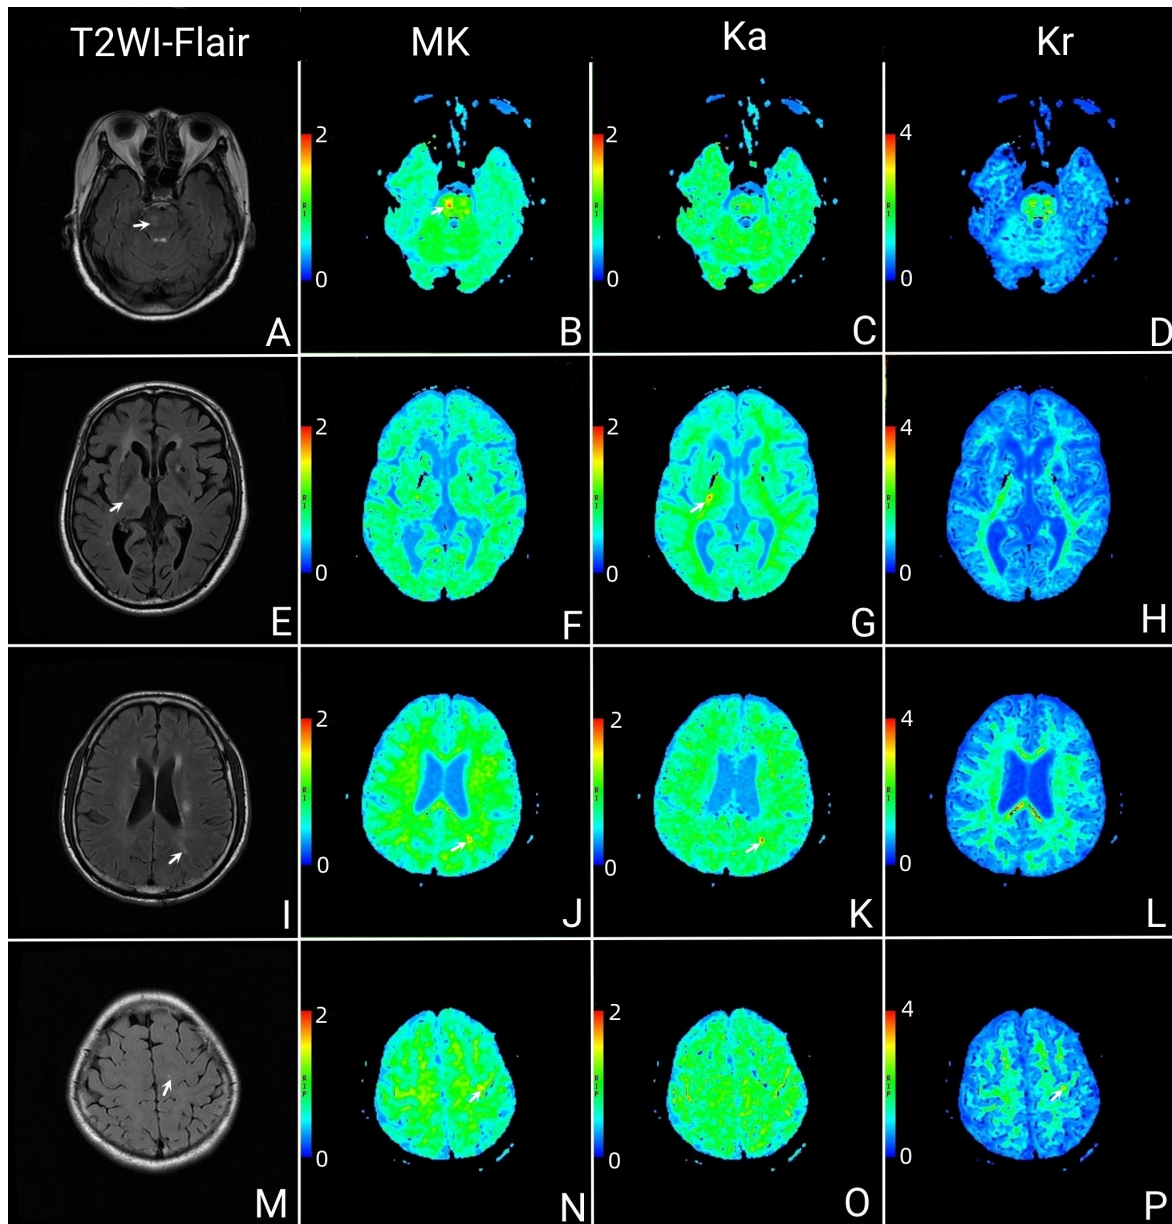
Characteristics of lacunar infarct foci in different brain regions of the CST on DKI. The lesion within the pons showed high signal on Flair (A, white arrow), and it was most prominently depicted in the MK maps (B, white arrow). Lesions within the pons were barely visible in the Ka maps (C) and Kr maps (D). The lesion within the PLIC showed high signal on Flair (E, white arrow), and it was most prominently depicted in the Ka maps (G, white arrow). Lesions within the PLIC were barely visible in the MK maps (F) and Kr maps (H). The lesion within the corona radiata showed high signal on Flair (I, white arrow). Lesion within the corona radiata was most prominently depicted in the MK maps (J, white arrow), but it was unclear displayed in the Ka maps (K, white arrow) and invisible in the Kr maps (L). The lesion within the subcortex showed high signal on Flair (M, white arrow). Lesion within the subcortex was most prominently depicted in the Kr maps (P, white arrow), but it was unclear displayed in the MK maps (N, white arrow) and invisible in the Ka maps (O). T2WI, T2-weighted images; Flair, fluid-attenuated inversion recovery; CST, corticospinal tract; DKI, diffusional kurtosis imaging. Note: (1) Diagnostic efficacy: The lesions were first found with the naked eye following a single-blind protocol, and the differences between the lesions and the mirrored normal brain areas were measured at the workstation. The DKI parameter map with the greatest difference between the lesion and the mirror normal brain area is defined as the one with the highest diagnostic efficacy (white arrow). (2) The diagnostic efficacy of MK, Ka, and Kr maps in identifying lacunar infarcts in different brain regions displayed variability. (3) The different rows of panels related to different patients.
